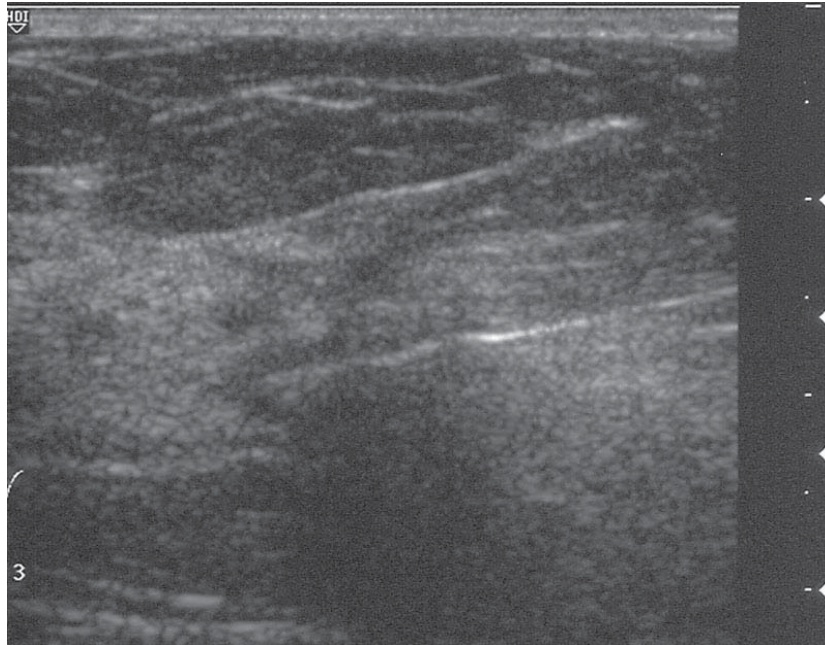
It shows a poorly attenuating lesion being transfixated with a hook wire under ultrasonographic guidance.
